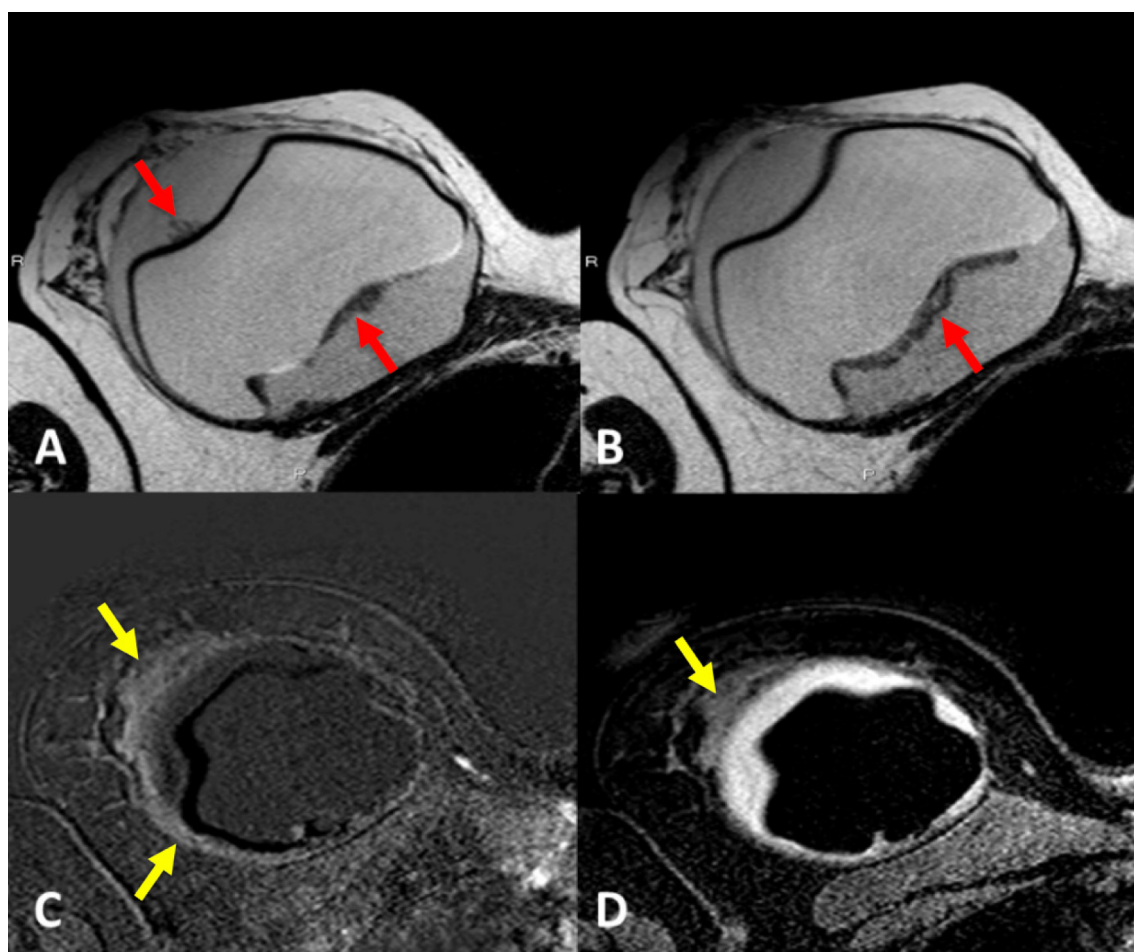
Case #1. MRI images: T2 sequences (A,B); subtracted T1 sequence after contrast material injection (C); T1 sequence after contrast material injection (D). Notice wide seroma between capsule and prosthesis: (A,B) amorphous material due to fibrin is appreciable on the inner surface of the fibrous capsule and on the outer surface of the prosthesis (red arrows); (C,D) the fibrous capsule appears thickened and hyperemic, especially in the anterior and lateral sectors (yellow arrows).
